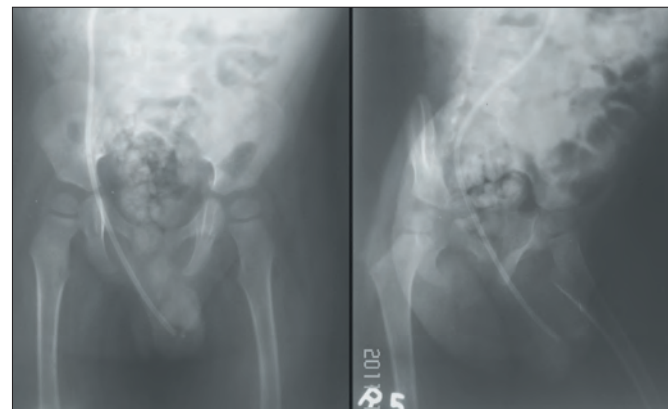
X-ray of the abdomen A-P and lateral view showing shunt migration into the right scrotum.
